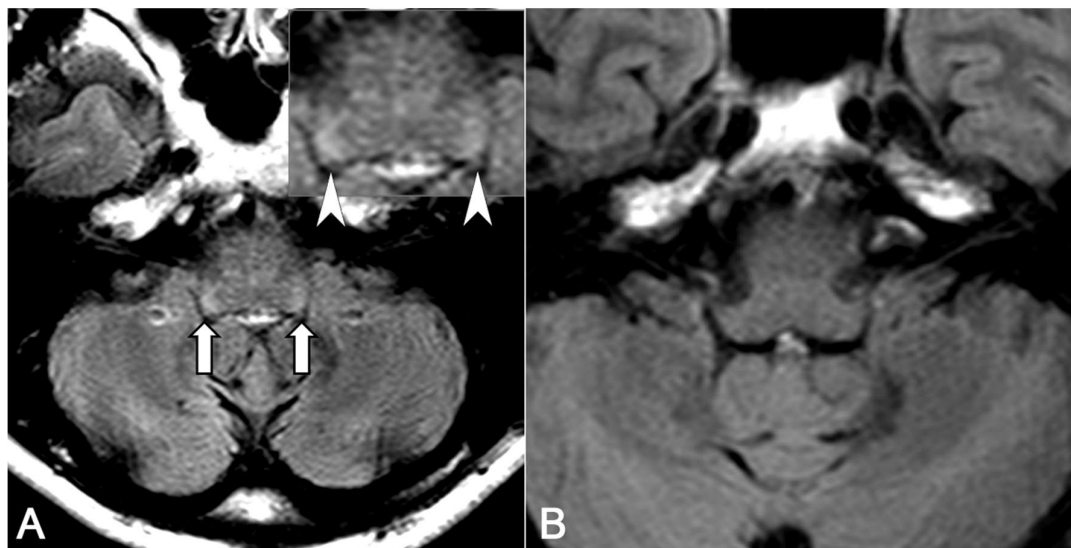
Representative cases of positive/negative inferior cerebellar peduncle (ICP) sign. (A) A 45-year-old female presented with cerebellar ataxia. FLAIR image reveals increased signal intensity in the bilateral cerebellar peduncles (arrows; arrowheads in an inset) compared to the medulla. The patient was diagnosed with MSA-C. (B) In the T2 FLAIR image of a 48-year-old male diagnosed as spinocerebellar ataxia (SCA), no ICP sign is seen.
